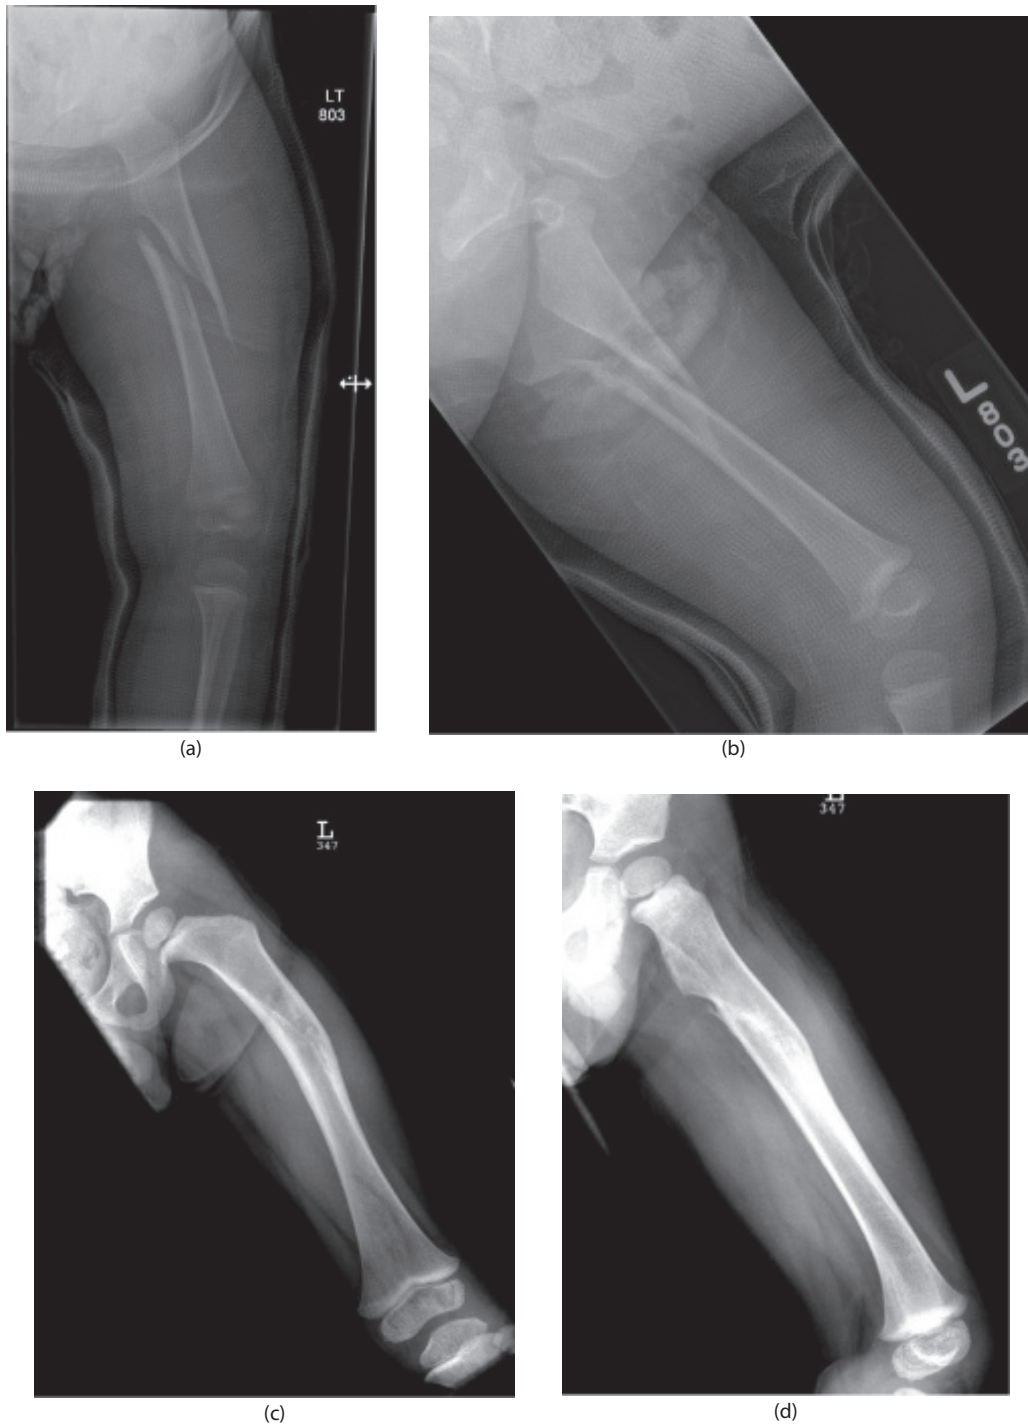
(a) and (b) Radiographs of a 3-year-old male with a femoral shaft fracture treated in a single leg spica cast. (c) and (d) Radiographs showing remodeling of his femoral shaft fracture 1 year after injury.
